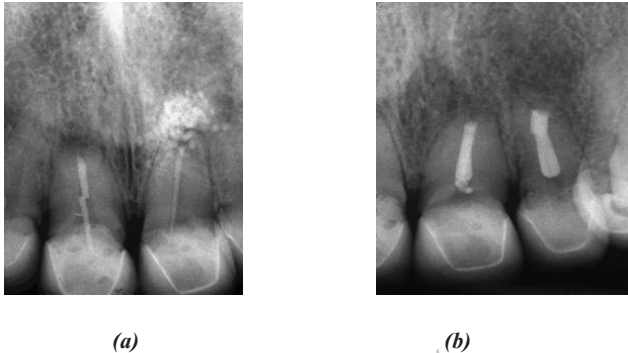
(a) Pre-operative radiograph of the upper central incisors. The root canals have been obturated with a surgical approach during the previous surgical procedure. (b) The root canals have been prepared using in sequence the long tips and obturated with thermoplastic gutta-percha and white MTA in the apical 3 mm.
